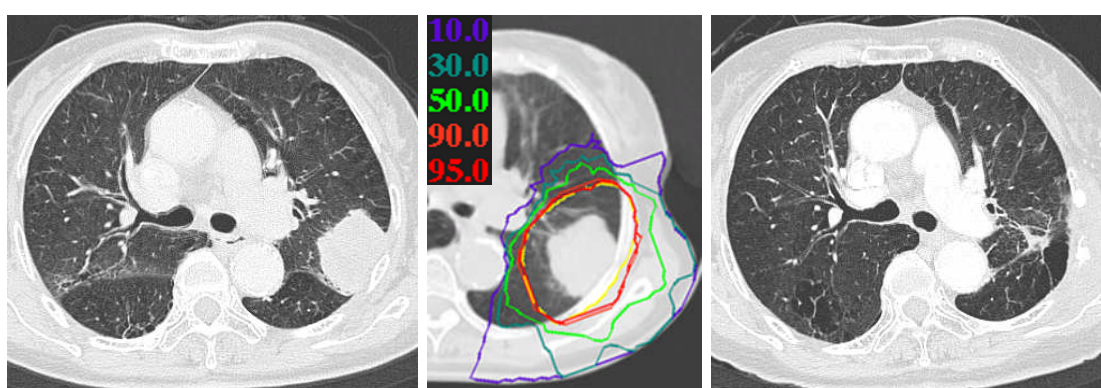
The clinical course of a 71-year-old female (T2N0M0 squamous cell carcinoma) after CIRT (40GyE/ single fractionation). The initial CT (A), dose distribution map (B), and CT (C) at 18 months after CIRT are shown. Apparent tumor shrinkage was observed without severe lung fibrosis.
